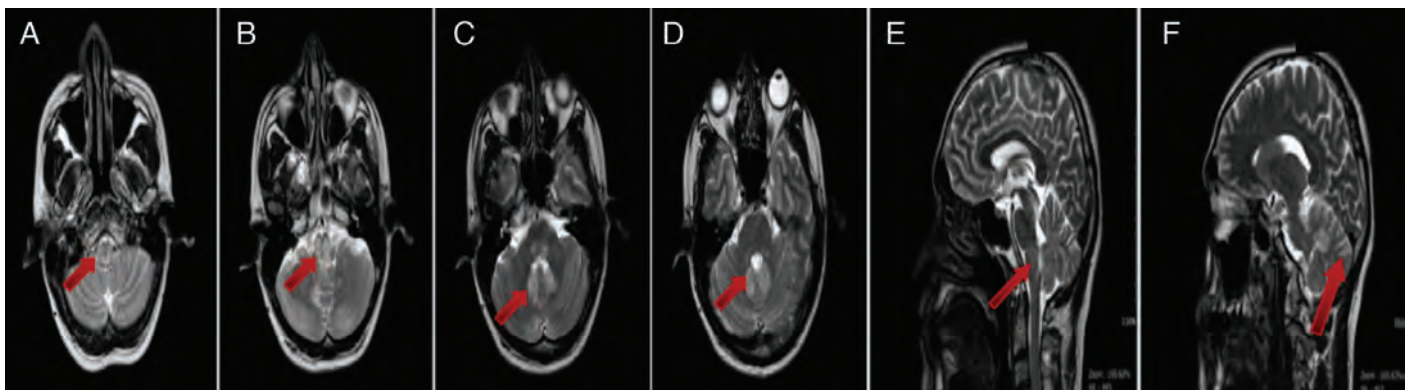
Axial (A-D) and sagittal (E, F) T2-weighted MRI sequences showed symmetric hyperintense lesions in the pons, bulbus, mesencephalon, and cerebellum
